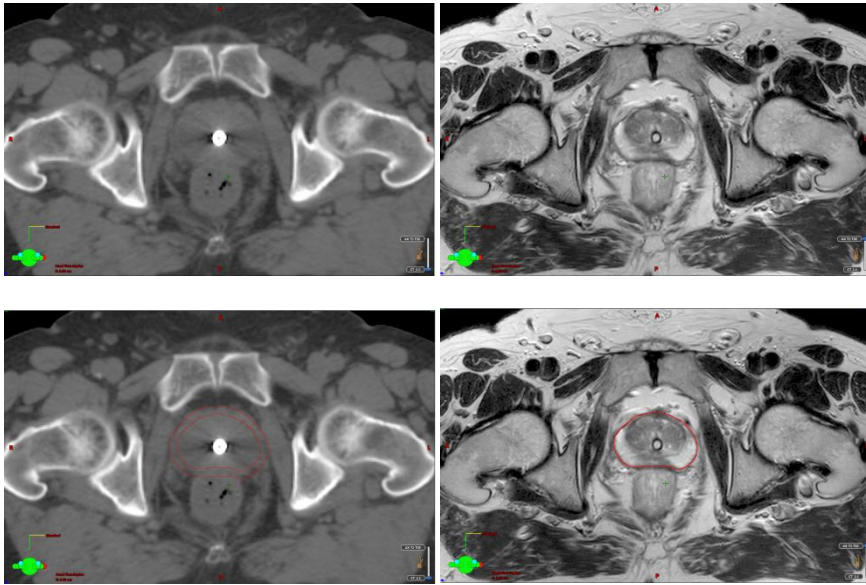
Superior soft tissue differentiation is seen on MRI compared to CT. Left pictures: Prostate delineation on CT. Right pictures: Prostate delineation on MRI.
